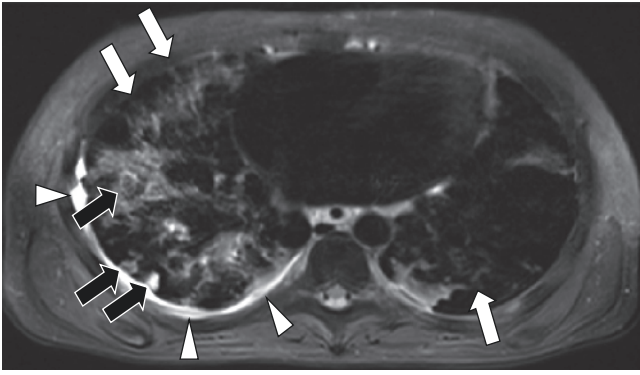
Mycobacterium tuberculosis infection in 13-year-old boy with immunosuppression. Axial non-enhanced T2-weighted MR image shows multiple hyperintense and ground-glass pulmonary nodules (black arrows), bilateral interstitial thickening (white arrows), and small right pleural effusion (arrowheads)
